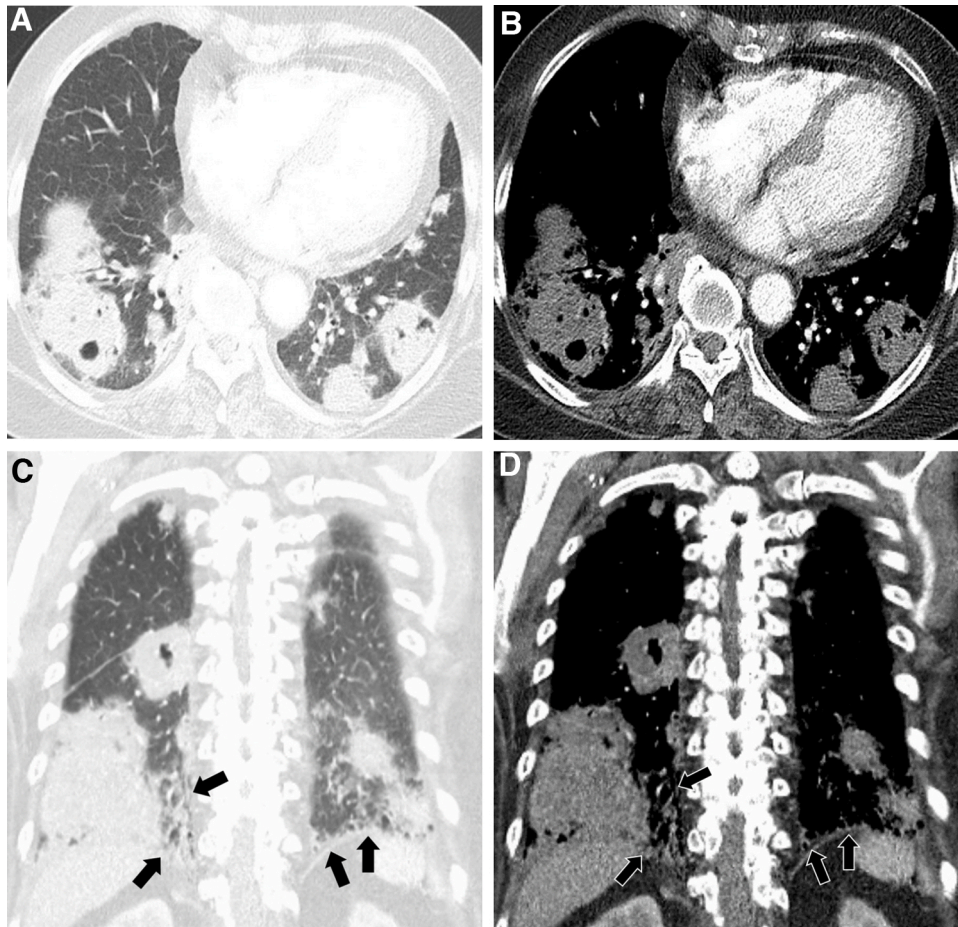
A subsequent chest CT shows multiple nodules and masses with internal cavitation in both lungs. Pulmonary thromboembolism and pleural effusion were not observed; however, reticulation and ground-glass opacities with traction bronchiectasis were detected in the posterior basal segment of the right lower lobe (arrows).
